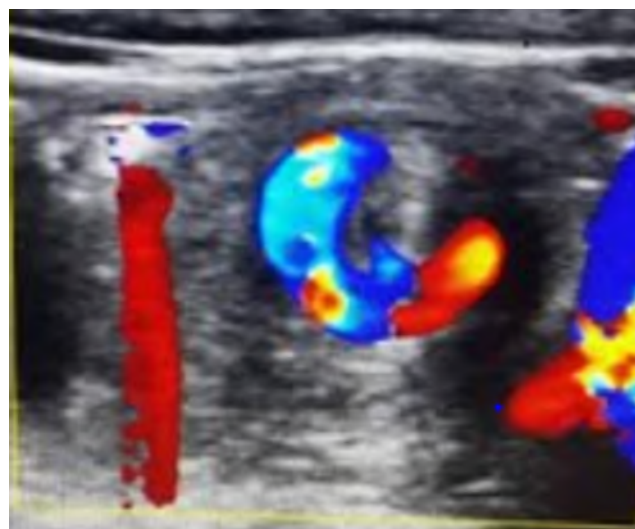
Transversal ultrasound section showing a hyperechoic mass with a spiral twist
